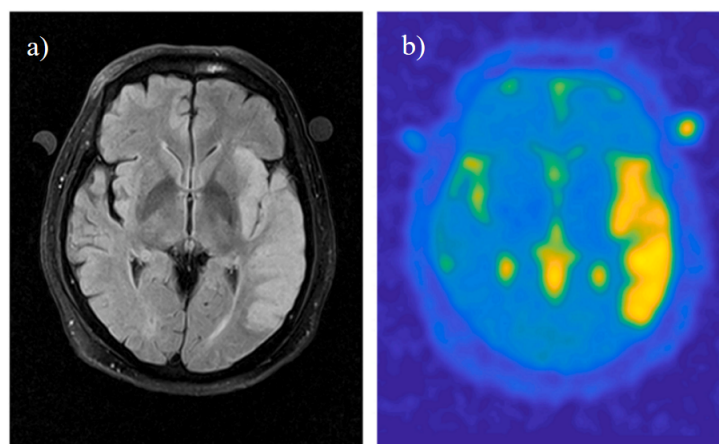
Ischemic stroke imaging example: a) ^1H FLAIR image and b) ^{23}Na MR image
